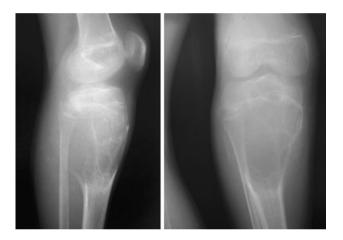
Radiographs performed after 3 months showing the aggressive nature of the ABC with marked cortical attenuation, especially over the posterior aspect. An osteolytic area is also visible in the proximal tibial epiphysis
